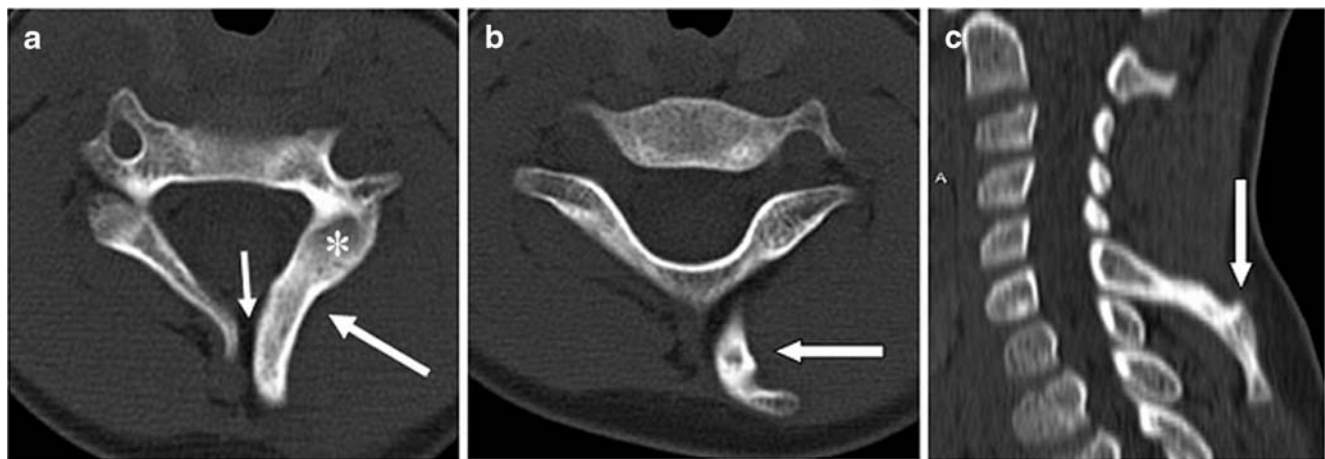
a–b Axial CT scans passing through C6 vertebra show the absence of pseudoarticulations at the base of the spinous process and within it (*arrow* in a and b). Schisis of the vertebral posterior arch (*small arrow* in a), and hypertrophy of the left lamina (*asterisk* in a)
